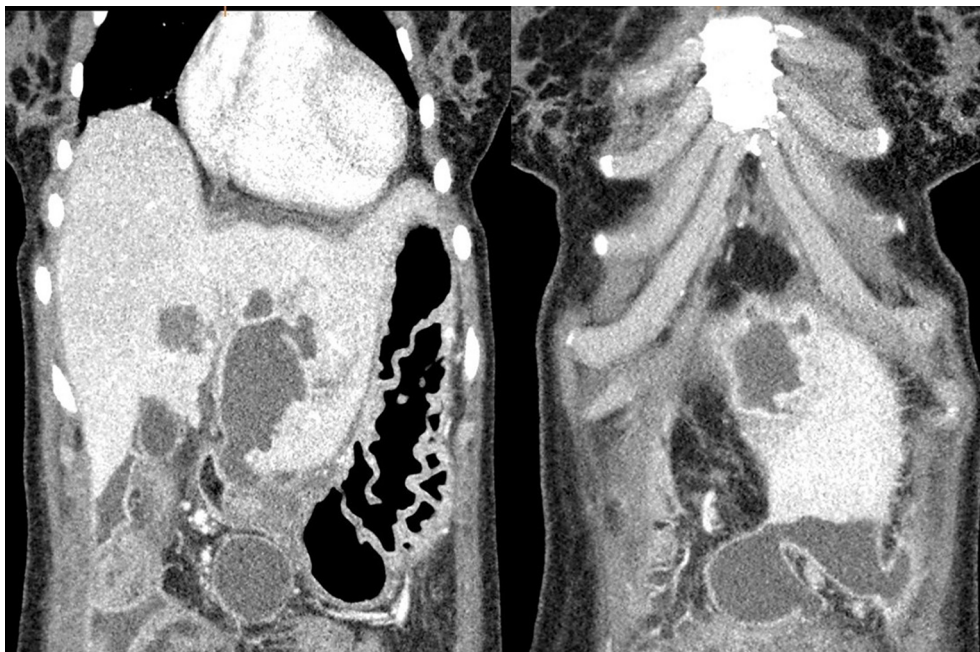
Two different coronal reformatted contrast-enhanced computed tomography images of the same patient show a perforated hydatid cyst located in segment III of the liver and fluid collection in the perihepatic/pelvic area.
